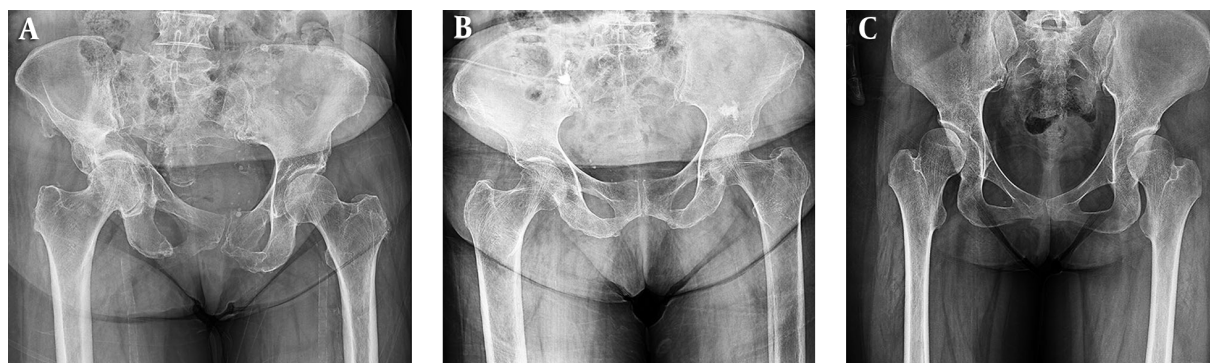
A, A Proximal Femur Radiograph with Complete Agreement on Type B of Dorr Classification; B, A Proximal Femur Radiograph with Complete Agreement on Type C of Dorr Classification; C, A Proximal Femur Radiograph with Half Agreement on Type B and Half Agreement on Type C of Dorr Classification.
